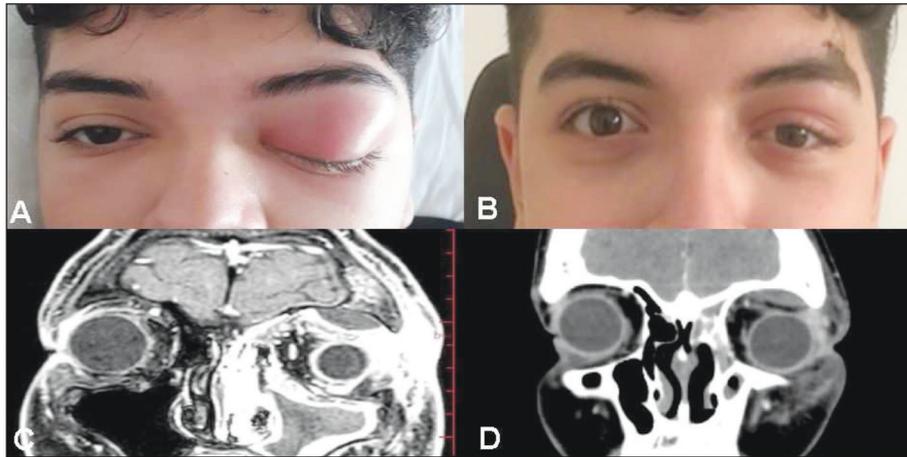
Images of a 16-year-old patient with left pansinusitis and left superior SPOA, A) Preoperative clinical image shows marked left periorbital edema and hyperemia, B) Postoperative 1st week image shows significant improvement in left clinical findings, C) Contrast-enhanced coronal section T1 appearance of SPOA in the left superior on MRI, D) Appearance of superior SPOA on coronal section CT.
